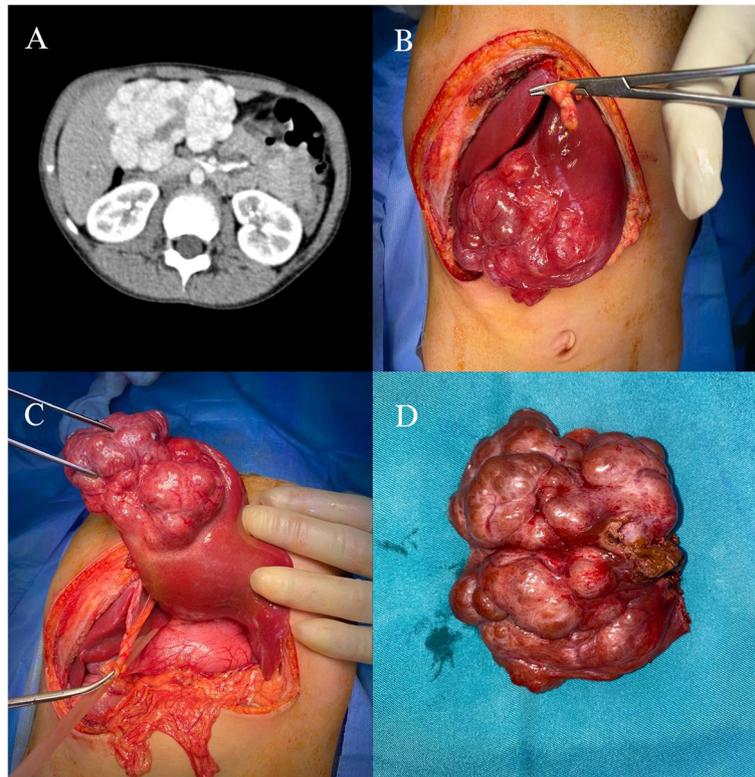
A Initial CT (axial view) shows focal nodular hyperplasia in segment III. B and C Operative photo shows tumor exposure. D segmental resection was performed with complete tumor resection
